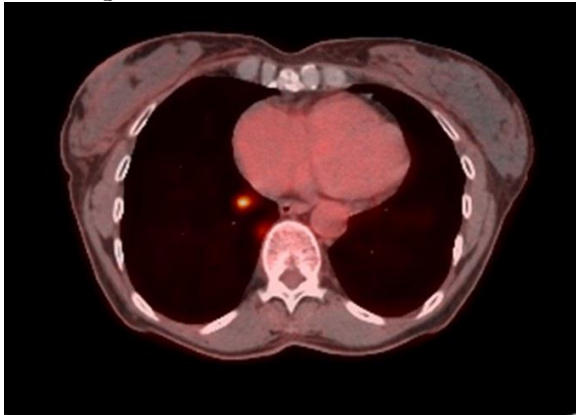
Image from PET scan done November 2023 showing increased fludeoxyglucose F18 (FDG) uptake in the RLL. To view figure 2 in a separate, enlarged window click [here](#).
